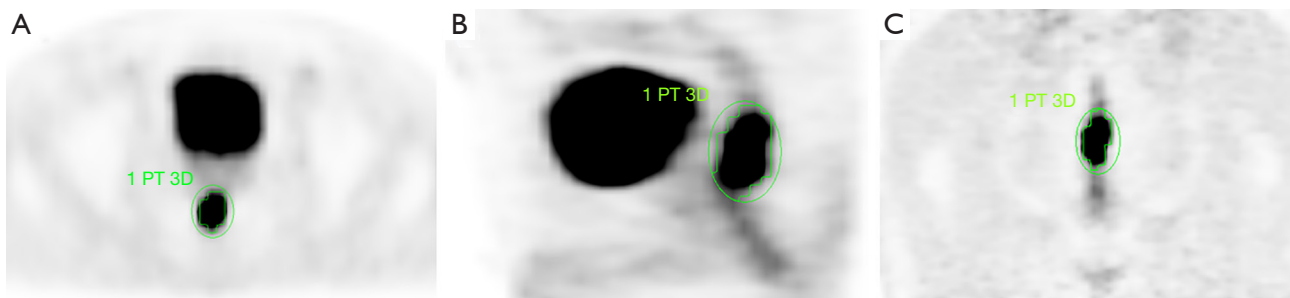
The contouring margins of the tumor lesion were automatically derived and manually adjusted on axial (A), sagittal (B), and coronal (C) planes in the ^{18}F -FDG PET/MRI image to ensure accurate inclusion of the primary tumor. PT, positron emission tomography; ^{18}F -FDG PET/MRI, fluorine-18-fluorodeoxyglucose-positron emission tomography/magnetic resonance imaging.
